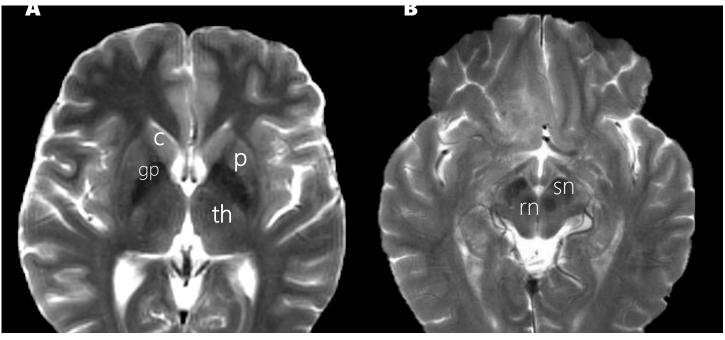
Deep grey matter nuclei as seen on T2-weighted axial MR images.
